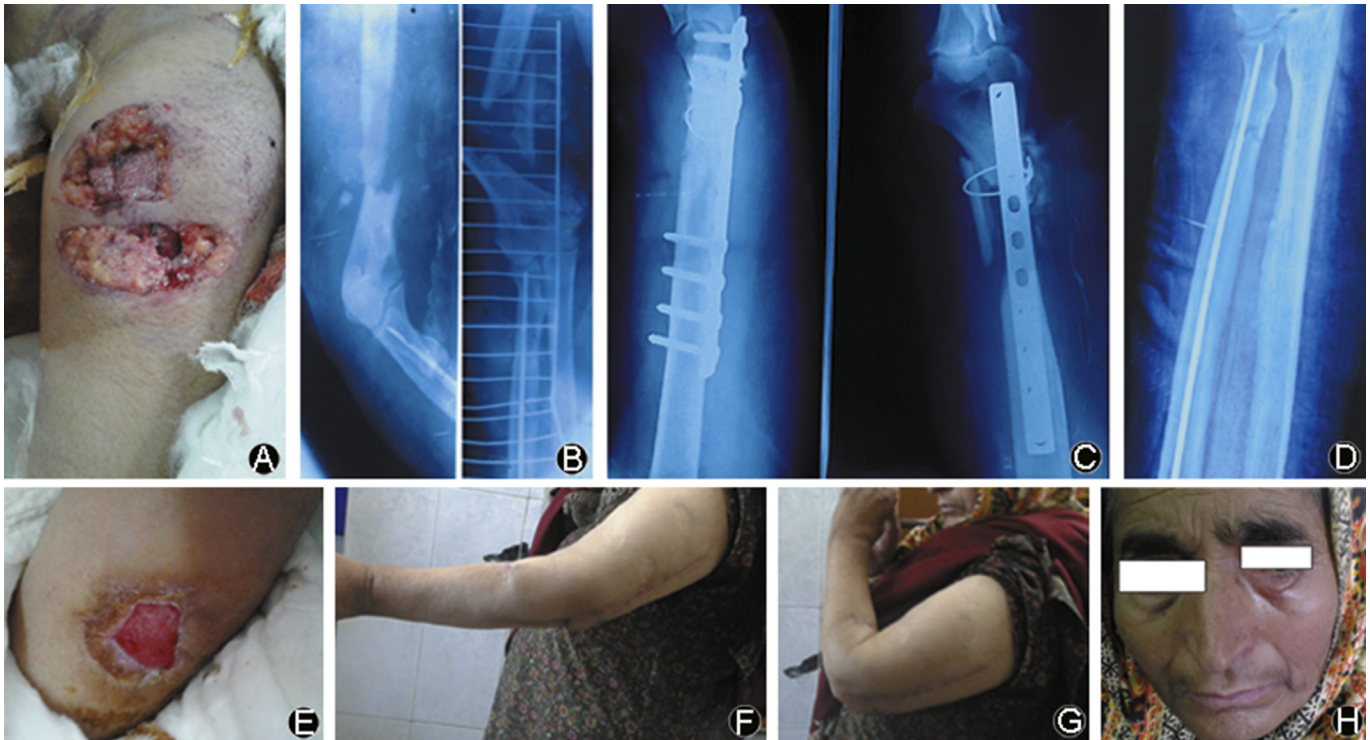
Case 1: A patient with severe upper limb injuries and milder facial/scalp injuries. A: Wound over proximal forearm (claw maks); B: X-ray showing shattered distal humerus and proximal radius fracture; C: Open reduction and internal fixation with plating, cerclage and bone grafting done; D: Square nail in situ for radius fracture; E: Wound healed (secondary intension); F and G: Healed wound and healed surgical scar with good range of motion at elbow; H: No gross facial injury (a small healed scar under left eye lid).
